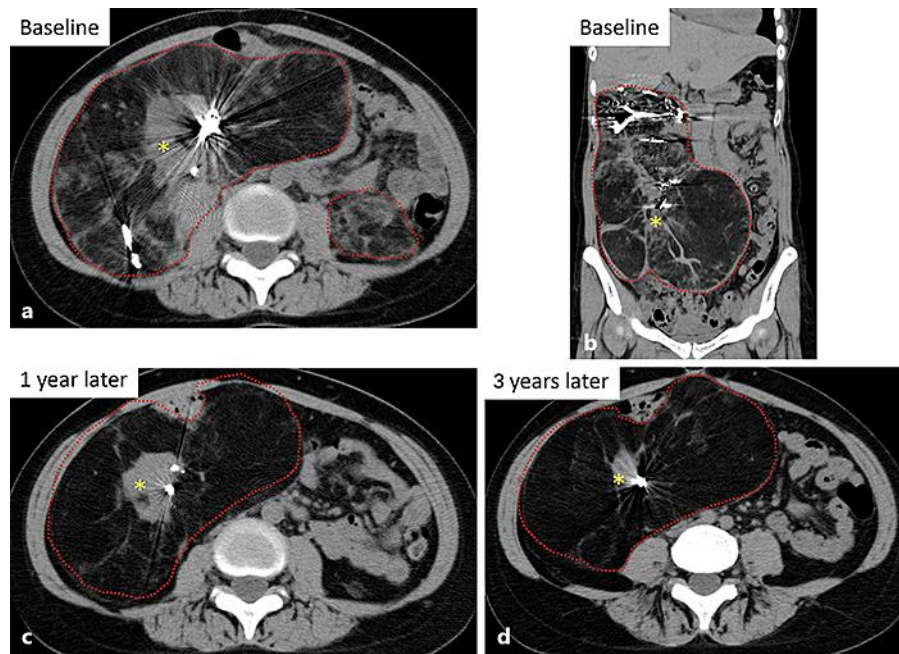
Case 2. a, b Computed tomography (CT) reveals huge RAMLs before initiation of everolimus therapy. The maximum diameter of the biggest RAML (asterisk) is 28 cm. c CT shows huge RAMLs at 1 year after initiation of everolimus therapy. The maximum diameter of the biggest RAML (asterisk) is 22.1 cm. d CT shows huge RAMLs at 3 years after initiation of everolimus therapy. The maximum diameter of the biggest RAML (asterisk) is 23.1 cm.
